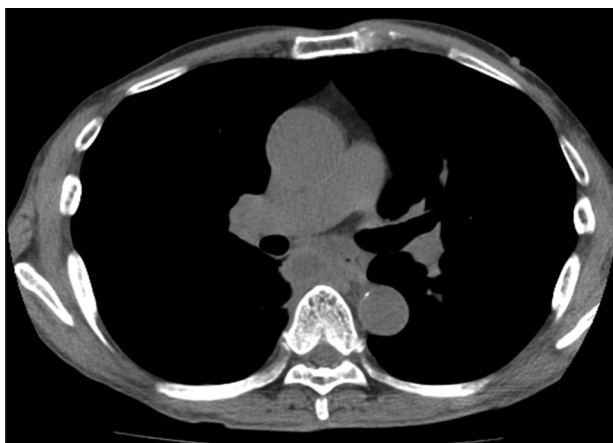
A chest computed tomography scan 4 weeks after the endoscopic ultrasonography drainage procedure showed a smaller lesion.
